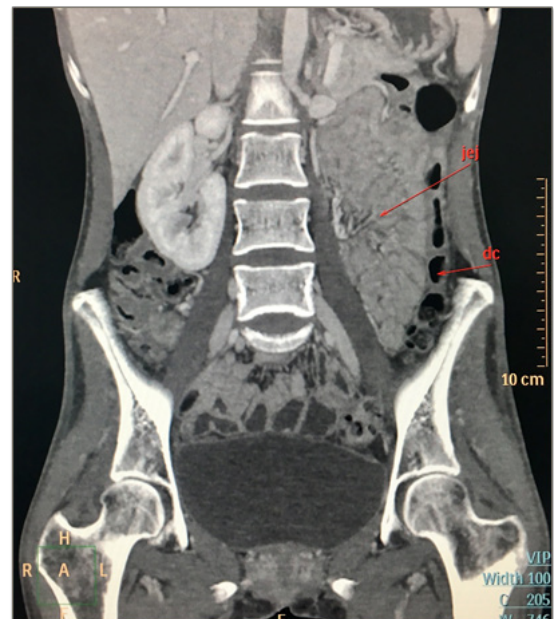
Abdominal computed tomography scan demonstrating collapsed bowels distal to the obstruction in this view (jej - jejunum, dc - distal colon)
